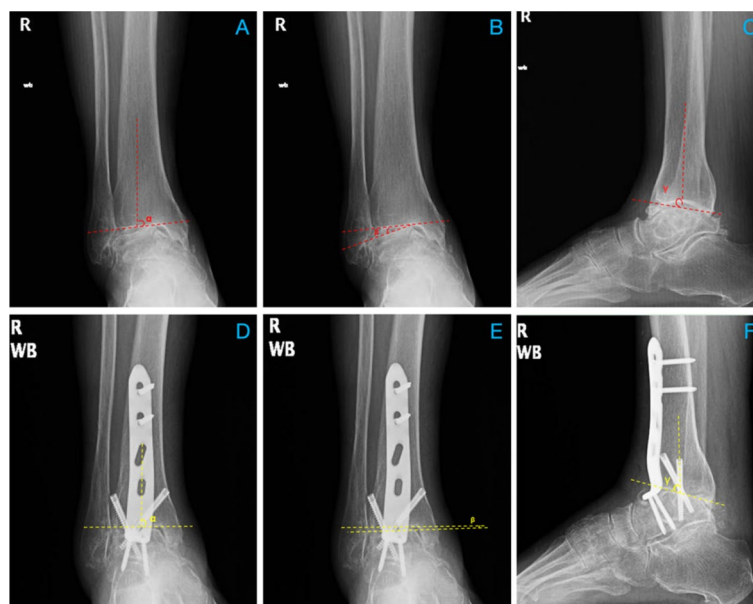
Preoperative weight-bearing X-ray images of the right ankle showing Takakura stage III B arthritis and the radiographic alignment indicators at the last follow-up, after ankle arthrodesis was performed using two 4.0 mm cannulated screws and plate fixation through the anterior approach. The union status was good at the last follow-up. A. Preoperative anteroposterior X-ray shows the medial distal tibia (MDTA) (α). B. Preoperative anteroposterior X-ray shows the talus tilt angle (TTA) (β). C. Preoperative lateral X-ray shows the anterior distal tibia angle (ADTA) (γ). D. Anteroposterior X-ray at the last follow-up shows MDTA (α). E. Anteroposterior X-ray at the last follow-up shows TTA (β). F. Lateral X-ray at the last follow-up shows ADTA (γ)
